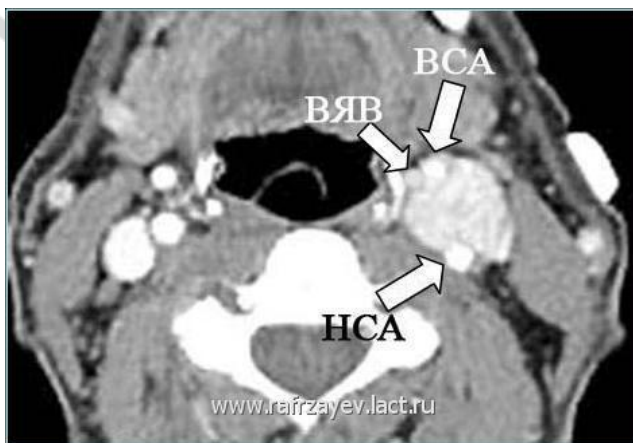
MRI with angiography identifies the topography of the tumor (online photo site www. Rafrzayev.lact.ru)
